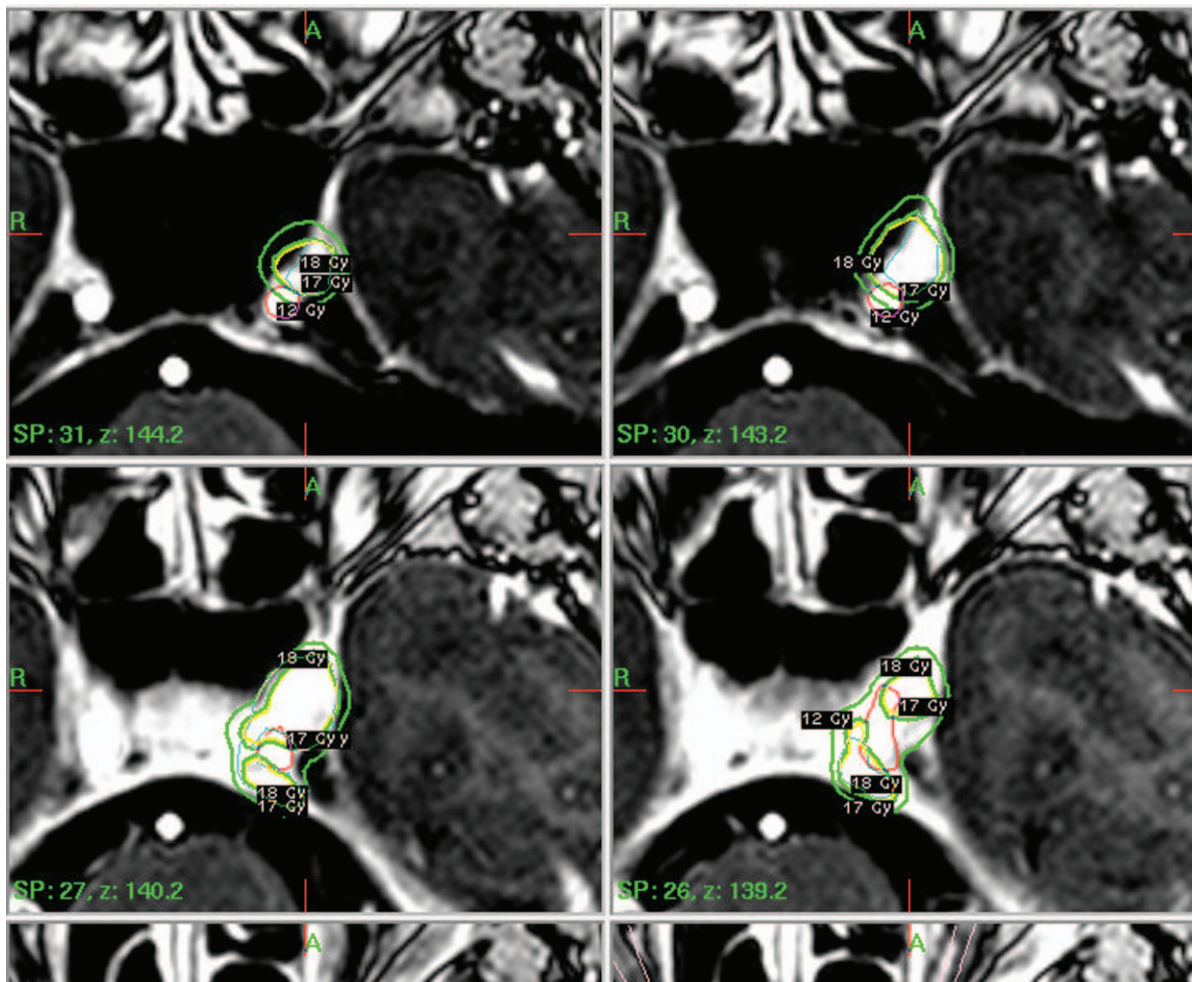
Axial treatment planning magnetic resonance imaging for gamma knife radiosurgery treatment showing the 50% prescription isodose line representing 18 Gy to the margin (yellow).
